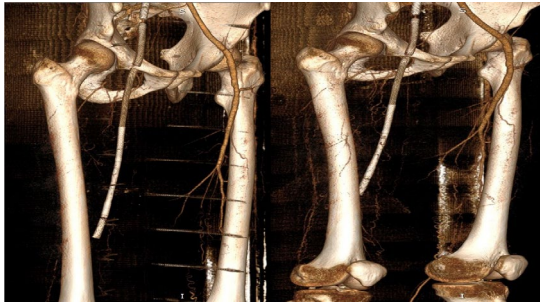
CT scan- left picture it's anterior-oblique view of the femoral part before ablation, where we can appreciate occluded stents with almost none collateral system on right and left leg; right picture its compared after 1 month after ablation, where we can appreciate newly formed large number of collaterals on medial and lateral femoral side starting from the pelvis down to the knee on both legs
